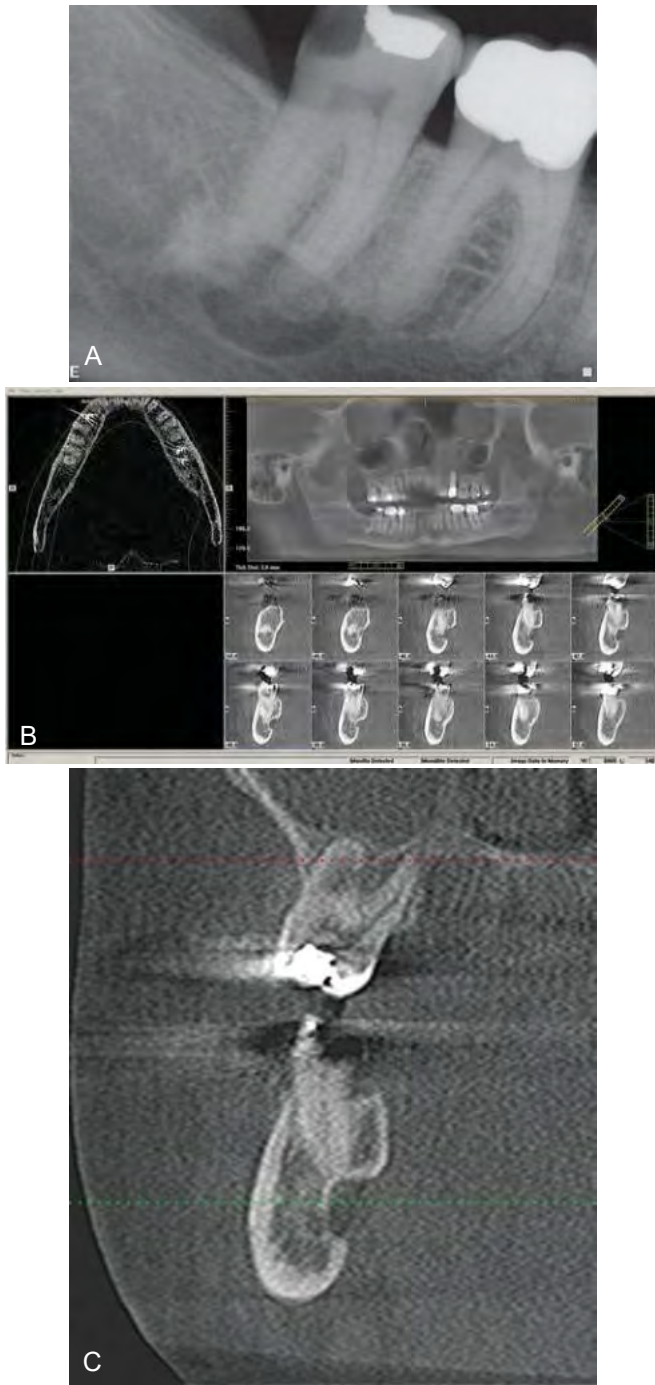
A, Periapical radiograph showing a large apical radiolucency associated with the mandibular second molar. Apical pathosis should be ruled out. B, Cone-beam volumetric tomography revealed Stafne indentation of the mandible in the area apical and lingual to the mandibular second molar, consistent with a Stafne defect. C, Enlargement of coronal section in the area of the mandibular second molar and the Stafne defect located on the lingual aspect of the mandible.
